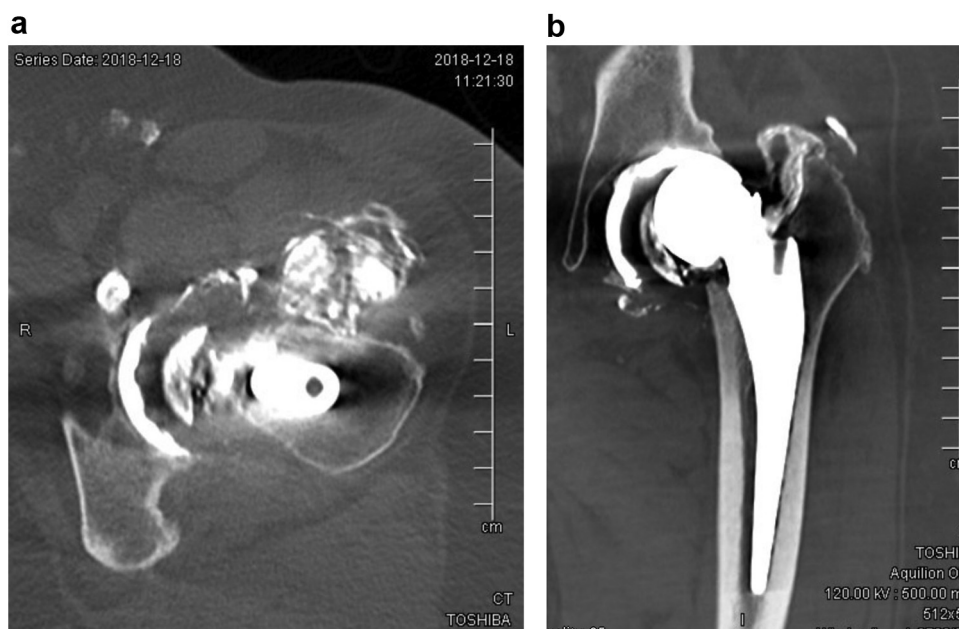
Axial (a) and coronal (b) computed tomography images of a failed oxidized zirconium THA with polyethylene liner dissociation and resultant Oxinium “arthrogram.”
